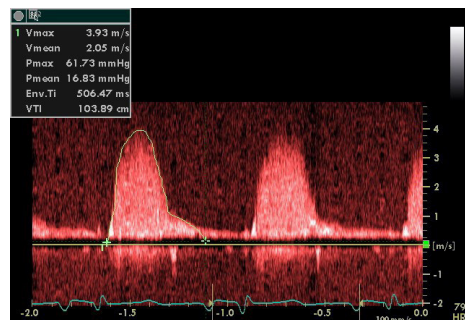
Echo Doppler Indicating Severe Pulmonary Valve Stenosis.
